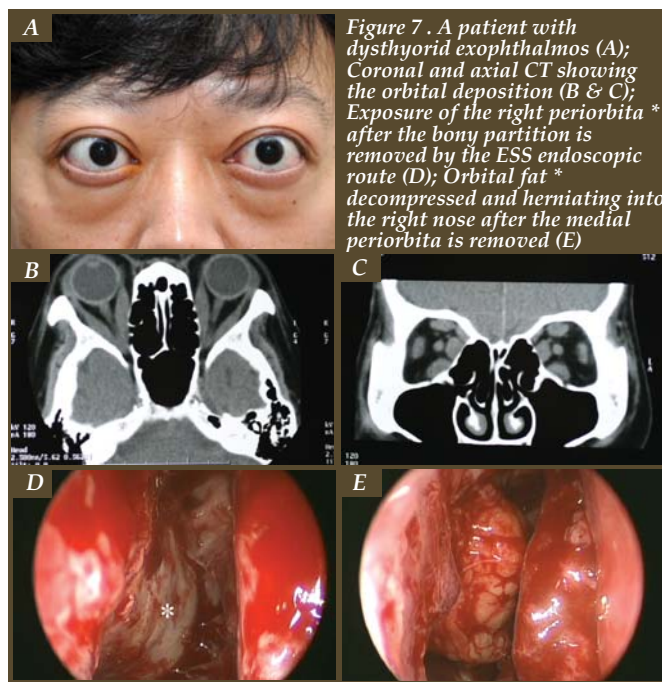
A patient with dysthyroid exophthalmos (A); Coronal and axial CT showing the orbital deposition (B & C); Exposure of the right periorbital \* after the bony partition is removed by the ESS endoscopic route (D); Orbital fat \* decompressed and herniating into the right nose after the medial periorbital is removed (E)
